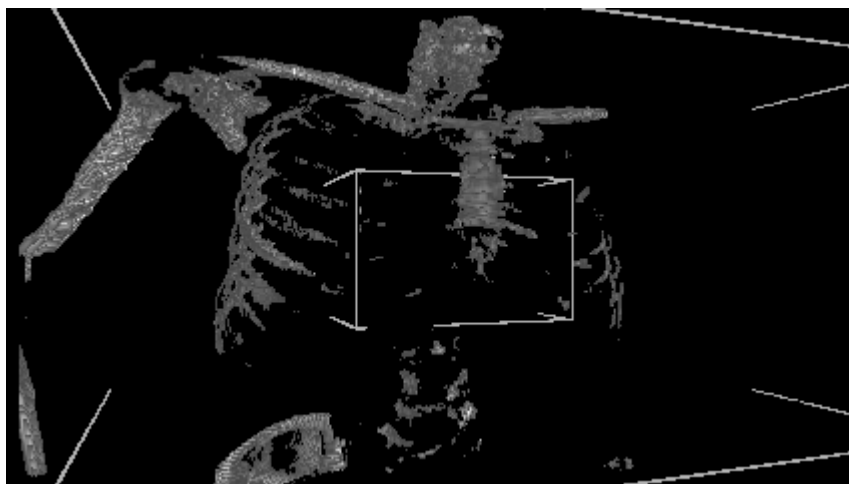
Right CT projection's negative parallax pixels.
